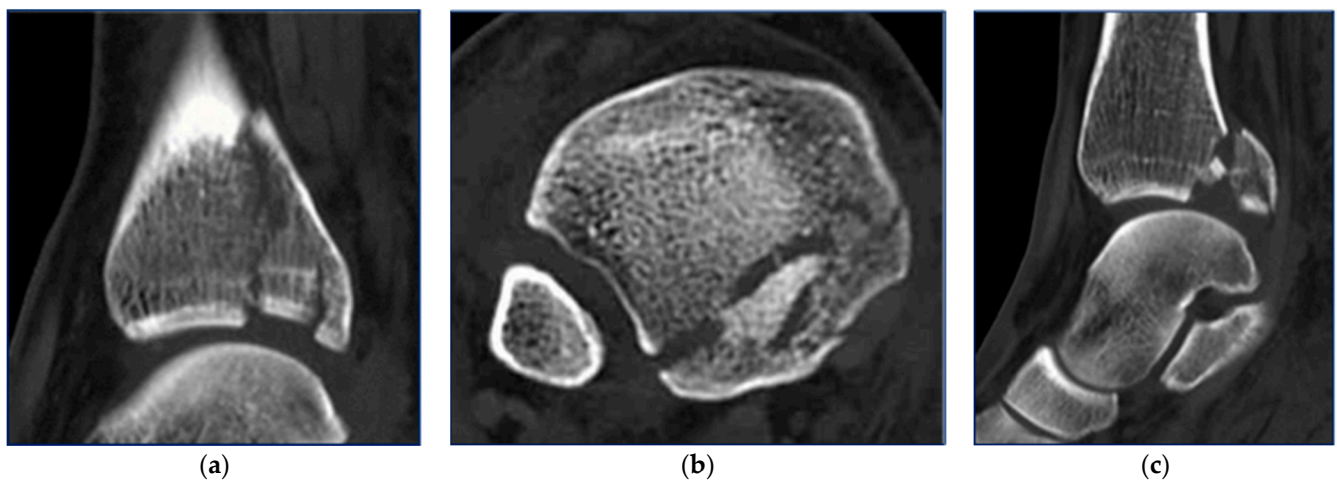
CT scan images of posterior malleolus fracture with plafond impaction (a), complex fracture margin, (b) and intercalary fragments (c).
